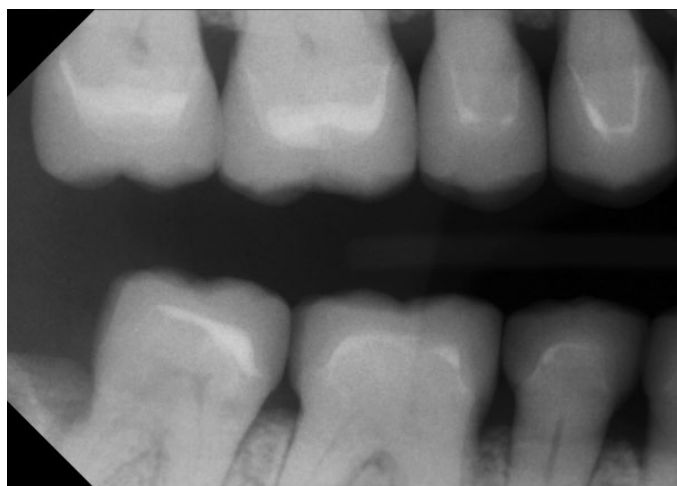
(A) Digital radiographs make it quick and easy to verify the interproximal fit of your prosthetic restorations before final seating.
